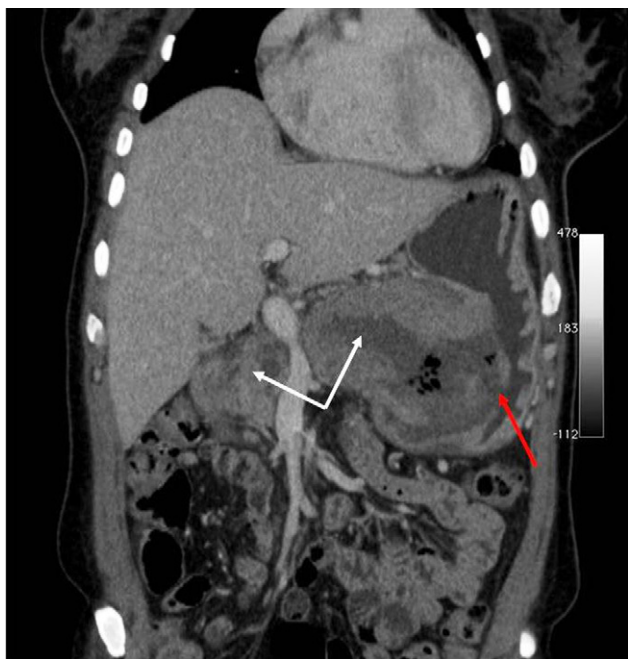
Abdominal computed tomography (CT), coronal view, shows solid and cystic lesions throughout the pancreas (white arrow) and an opening into the stomach (red arrow), with compression of the superior mesenteric vessels.
